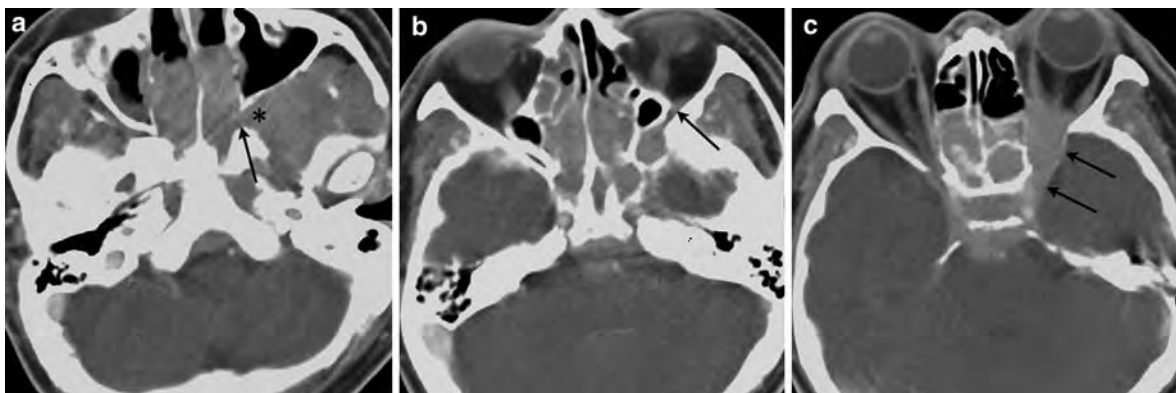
A series of three axial contrast-enhanced CT images from inferior to superior. Image a shows a nasopharyngeal carcinoma extending through an enlarged left sphenopalatine foramen (*arrow*) into the pterygopalatine fossa (*asterisk*).
